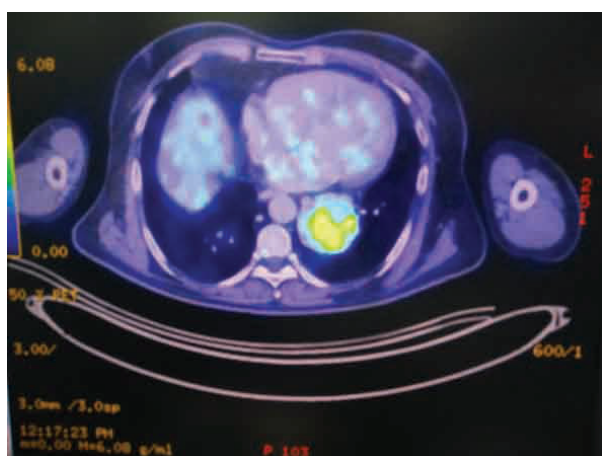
PET CT Showing Metabolically active Lesion in the left lower lobe of lung
